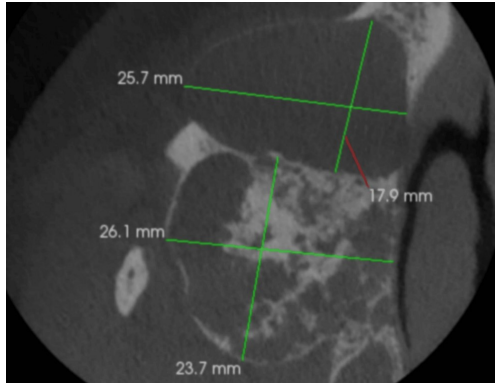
CBCT image showing axial dimensions of the cystic lesion with mixed radiolucent and radiopaque lesion in tuberosity suggestive of Fibro-osseous lesion.
